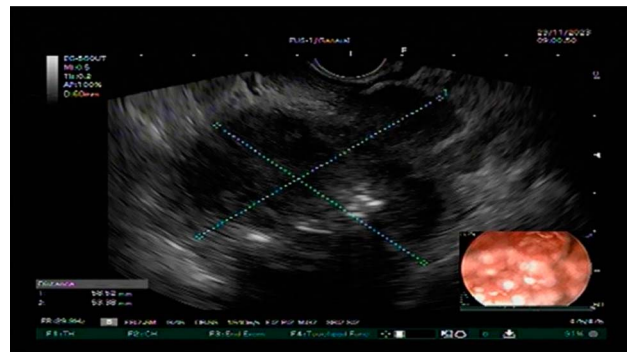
Endoscopic ultrasound shows a hypoechoic lesion measuring 55 mm × 65 mm compressing antrum.
